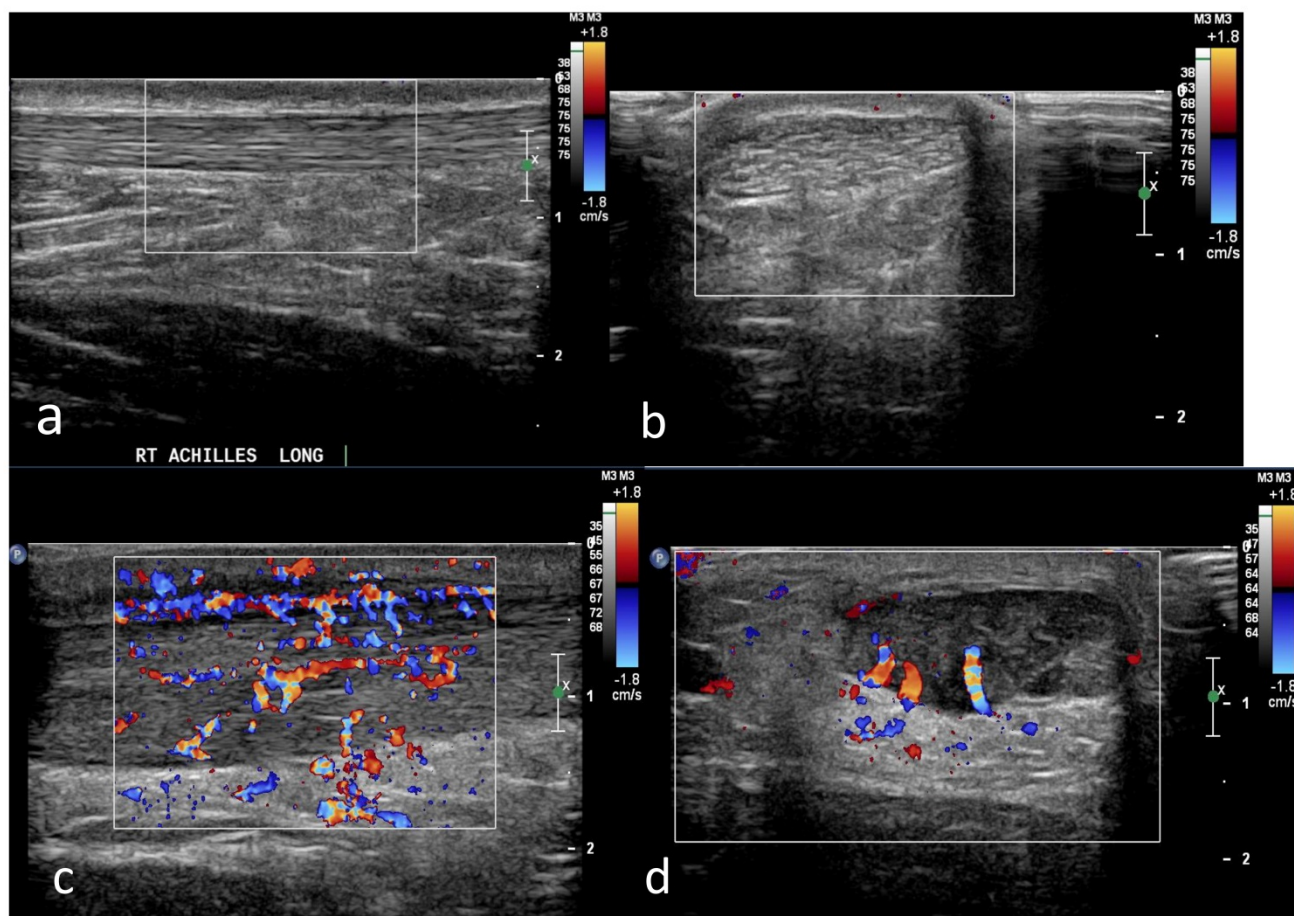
Ultrasound image of the Achilles tendon with Colour Doppler. (a) Longitudinal and (b) transverse image of a normal, asymptomatic Achilles tendon. Normal tendon echotexture with no Doppler signal. (c) Longitudinal and (d) transverse image of a symptomatic Achilles tendon. Significant thickening of the tendon with the presence of a hypoechoic changes. Significant Doppler signal is apparent within the tendon.
